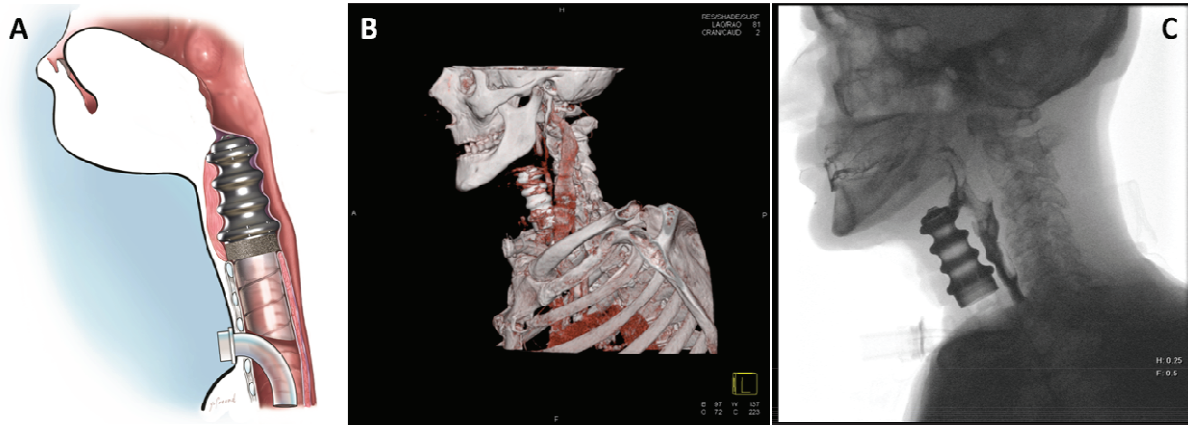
First step of implantation of Artificial Larynx (A) The Artificial Larynx system with the cap after the first surgical step (B) Cervical 3D CT scan showing the TP's good positioning after the first implantation step (C) Barium swallow test after the first implantation step confirmed absence of fistula.
